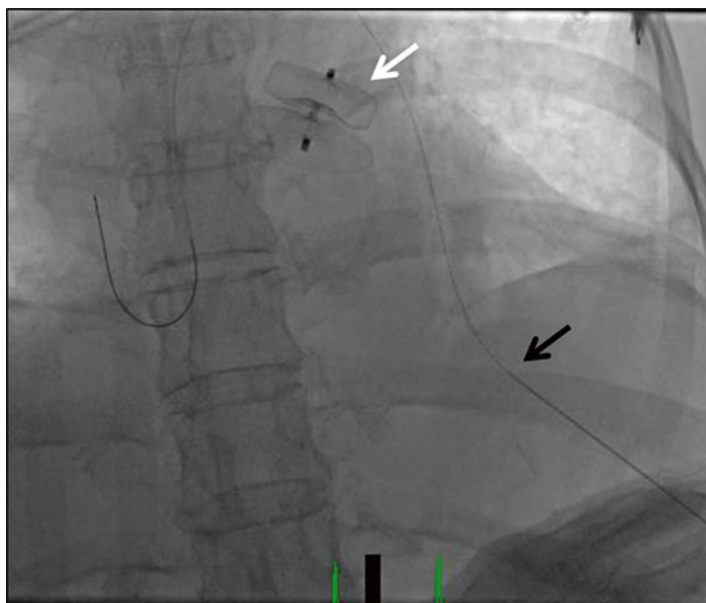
Acute pericardial effusion in 74 year-old female with clinical tamponade within 12 h of LAA closure with ACP device. Patient's body habitus and location of the effusion necessitated a parasternal approach to pericardiocentesis. Tip of micropuncture needle indicated by black arrow. ACP device indicated by white arrow
